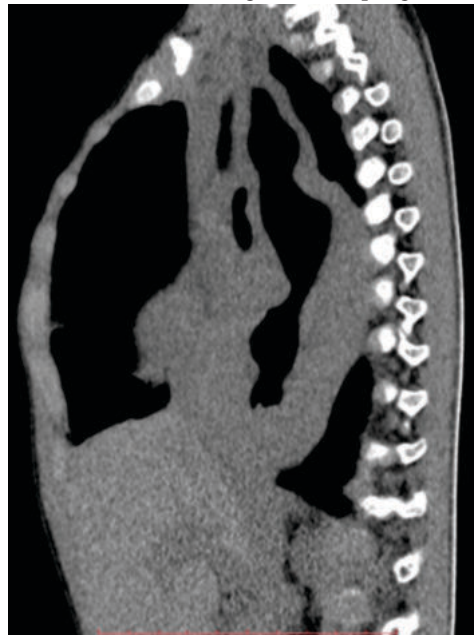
Sagittal CT Section In Mediastinal Window Showing The Extension Of Wall Thickening Till The Mid Esophagus.
